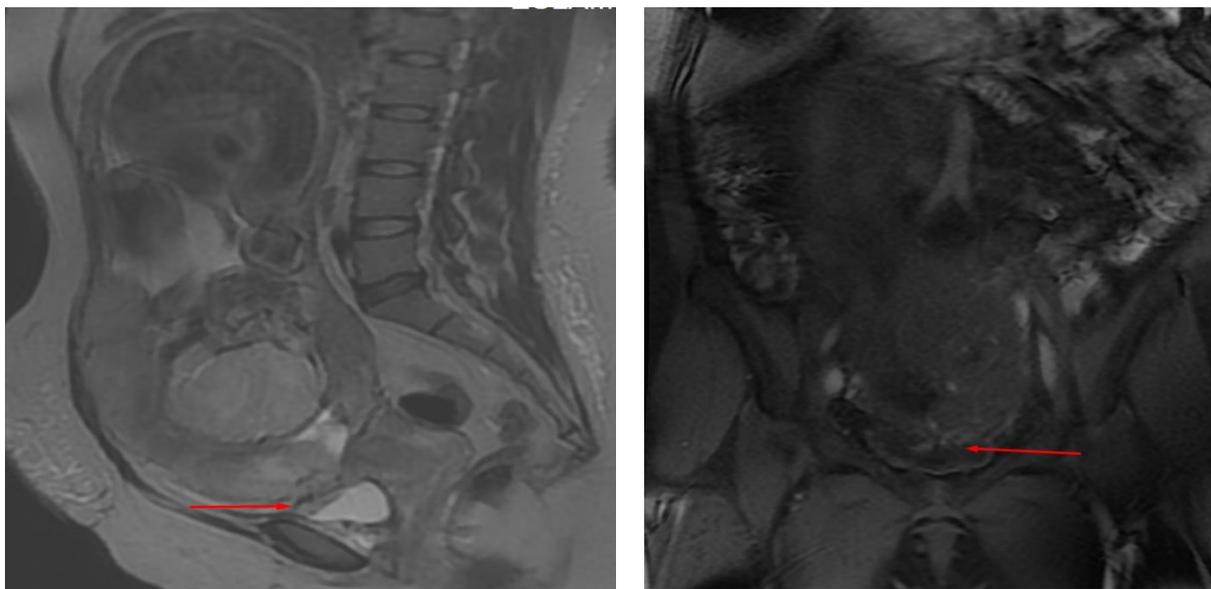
MRI scanning, T2 sagittal & coronal WIs & coronal T1 fat sat WIs revealed placenta previa & percreta with urinary bladder infiltration
